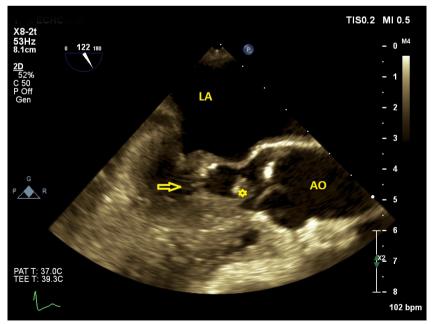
Figure- (A) Long-axis view of the aortic valve with 2-dimensional transesophageal echocardiography. The membrane in the left ventricular outflow tract (arrow) and vegetation (*) in the left ventricular outflow tract between the aortic valve and the membrane are visible. AO: Ascending aorta; LA: Left atrium. *Supplementary video files associated with this presentation can be found in the online version of the journal.
